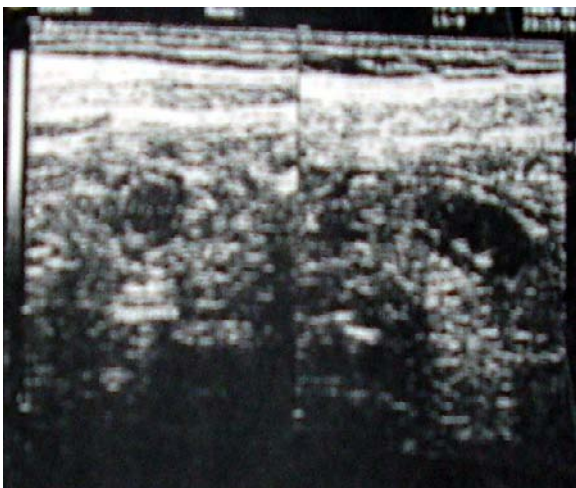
Transverse and longitudinal sonogram of acute appendicitis shows a target sign.
